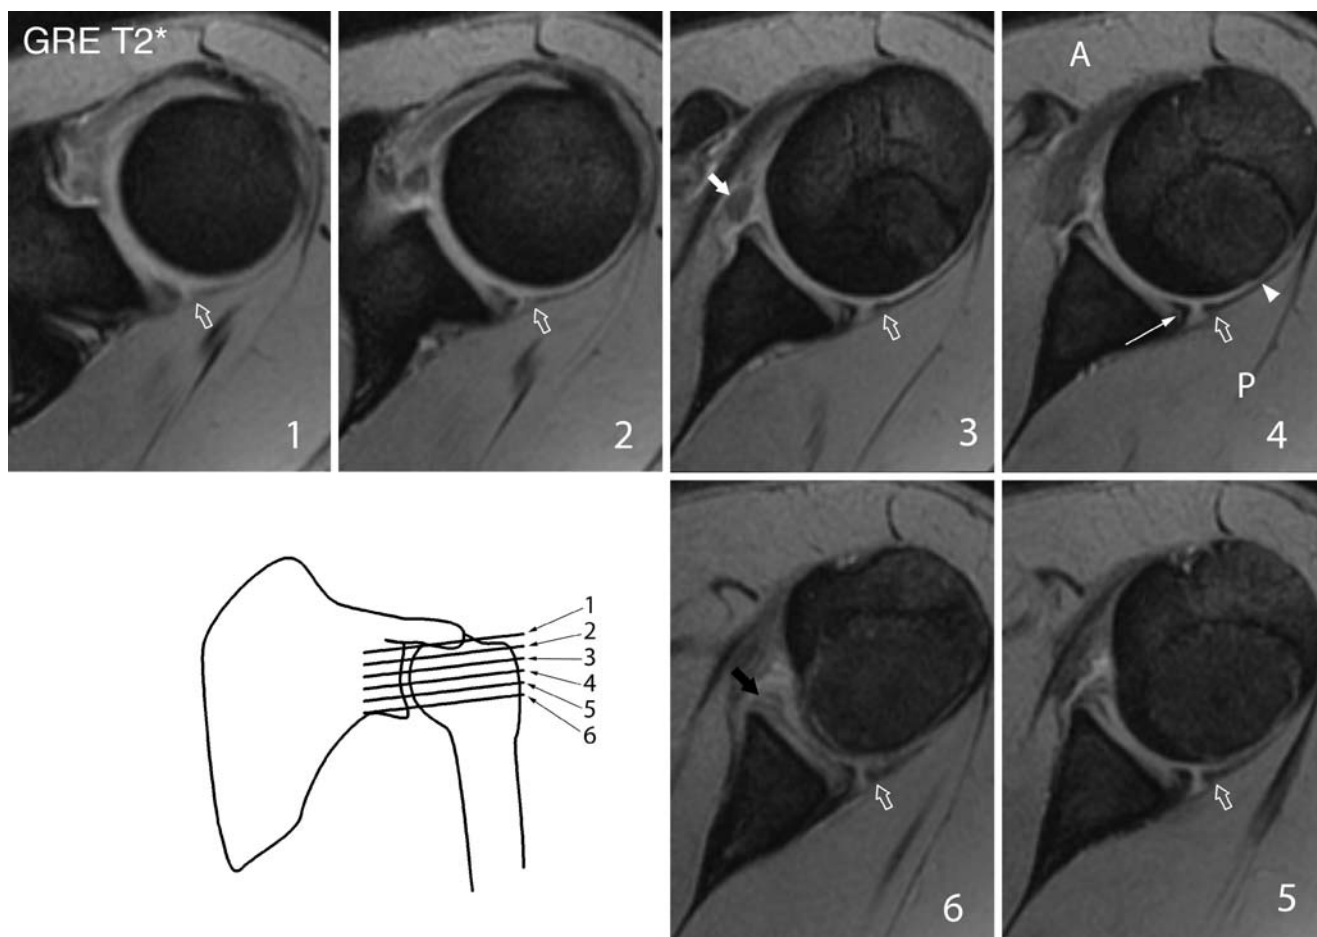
Shoulder MRI. Axial GRE T2* (TR 467, TE 15, flip angle 17°) Patient B: 16-year-old female with shoulder pain after trauma with anterior instability. *Open arrow* posterior synovial shoulder fold. *Long white arrow* normal posterior glenoid labrum. *White arrowhead* posterior shoulder joint capsule. 1–6 Axial T2* images from superior
